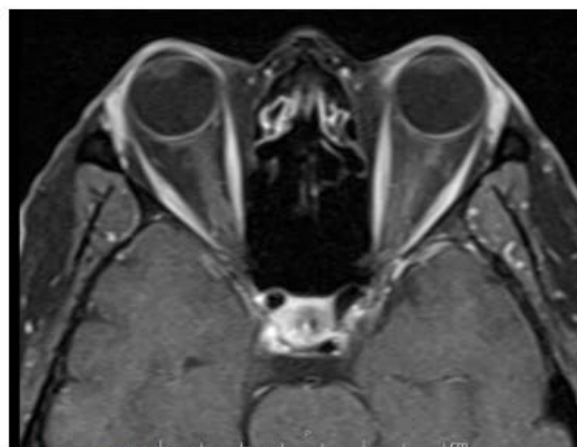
MRI orbits with contrast.
